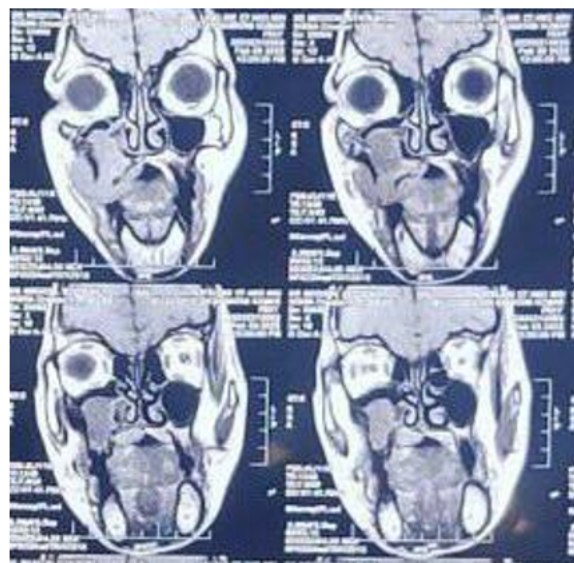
Pre-operative MRI nose and paranasal sinuses
